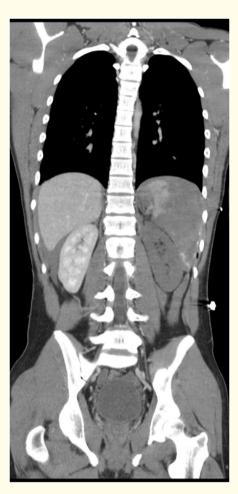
CT abdomen with not contrasted left kidney and laceration to the spleen.
